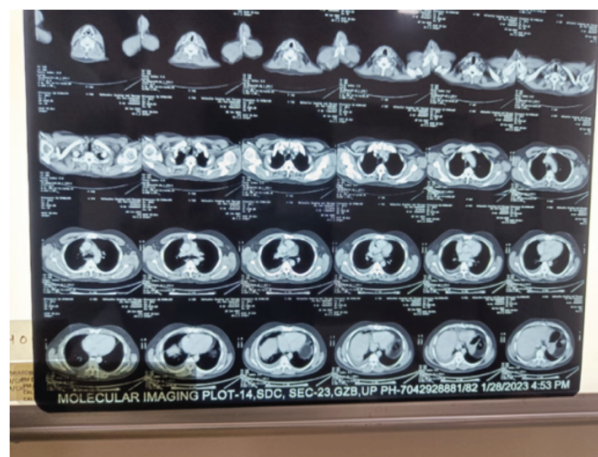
Post-procedural Computed Tomography (CT) of the chest.
